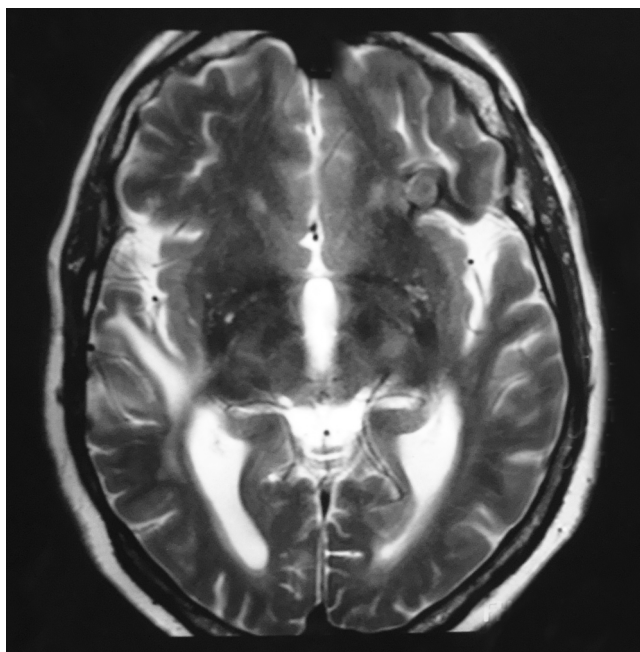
Magnetic resonance imaging showing partial reduction of brain metastases (2009).
